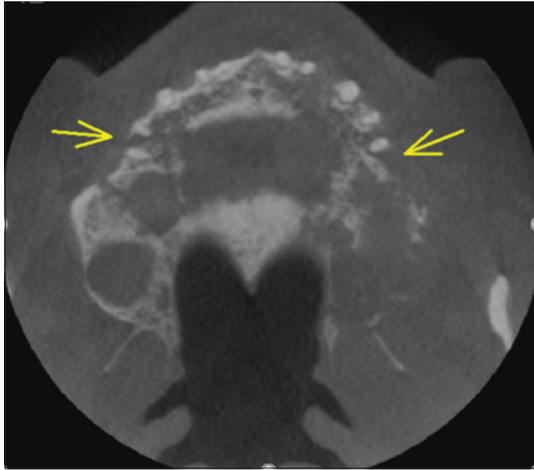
Axial computed tomography image showing mixed radiolucent radiopaque pathology with destruction of buccal and lingual cortical plates of the right and left sides
